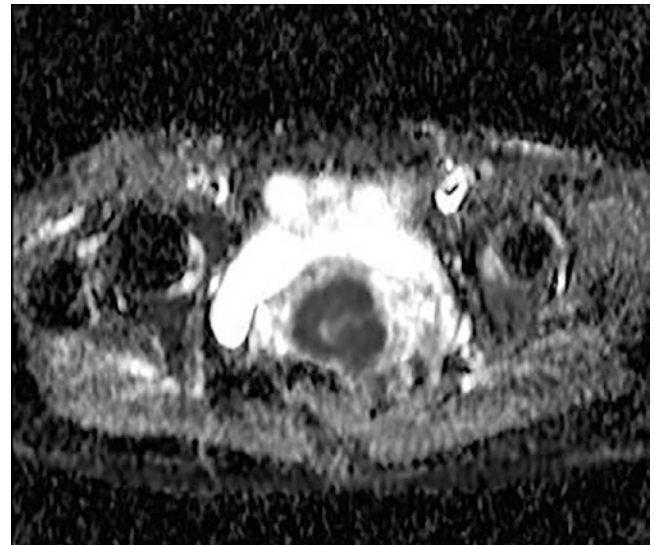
High signal on DWI and low signal on the corresponding ADC map
